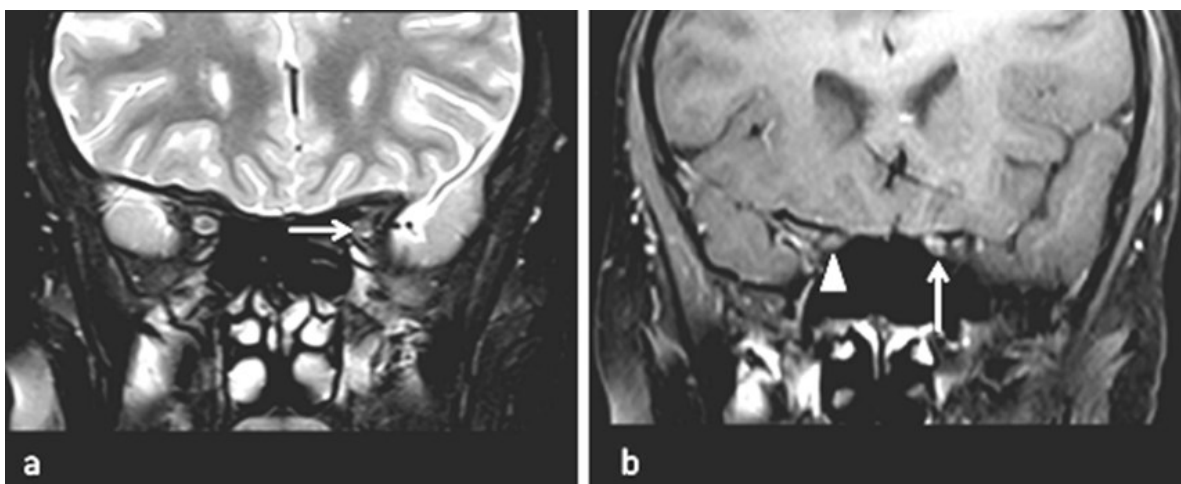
MRI brain and orbit of the patient on (a) coronal T2 fat saturation and (b) coronal post-gadolinium T1 fat saturation showing heterogenous signal in the left optic nerve within the optic canal with subtle enhancement of the nerve on post-gadolinium (white arrow) as compared to the right optic nerve (white arrowhead).
